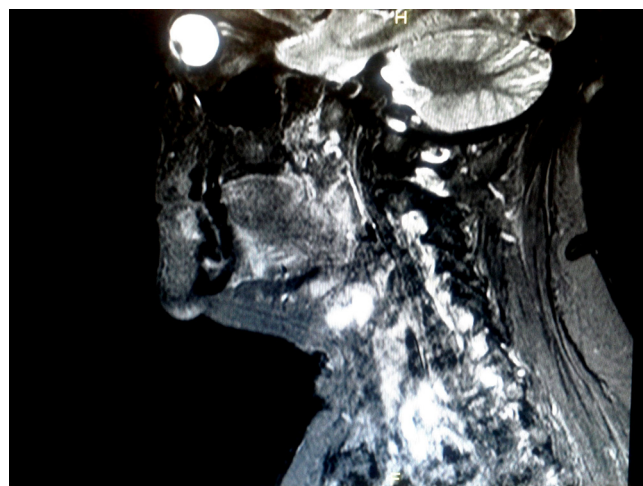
Neck MRI lateral projection.
